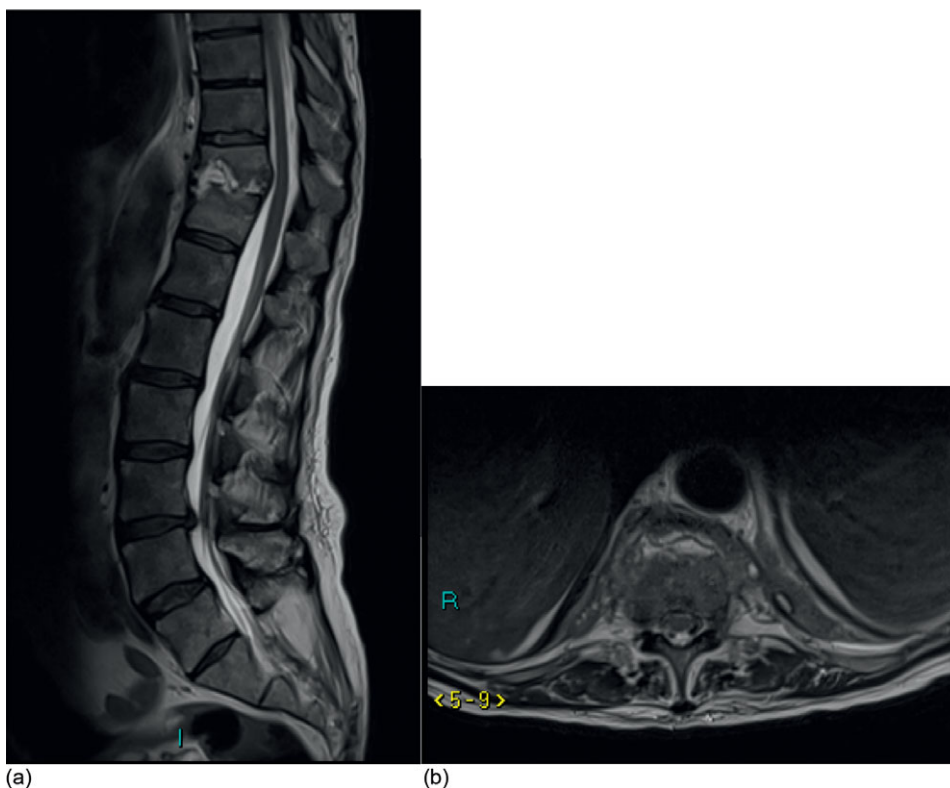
(a) Sagittal T2 and (b) axial T2 at level of interest MRI images thoracolumbar aspect
